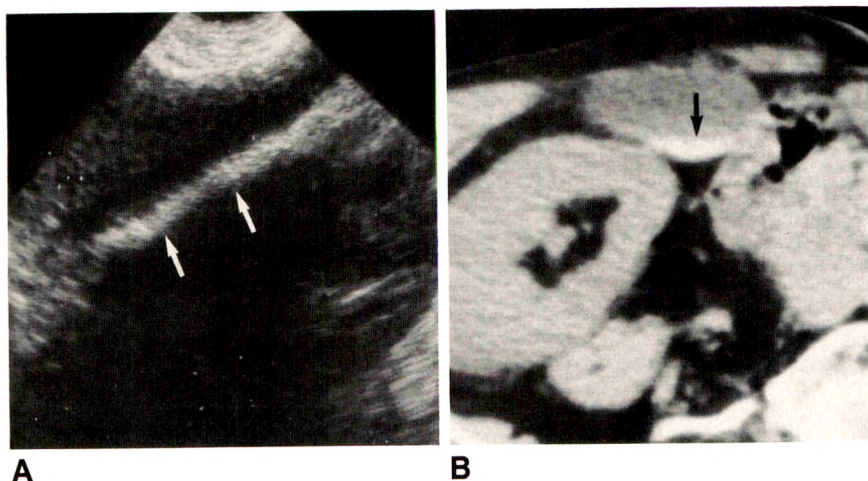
CT of cholelithiasis. No plain film calcification was detected.
